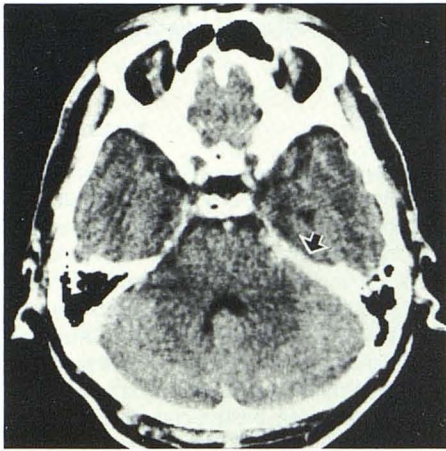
CT scan with contrast infusion showing slightly enhanced lesion (arrow) at right superior petrosal sinus.
